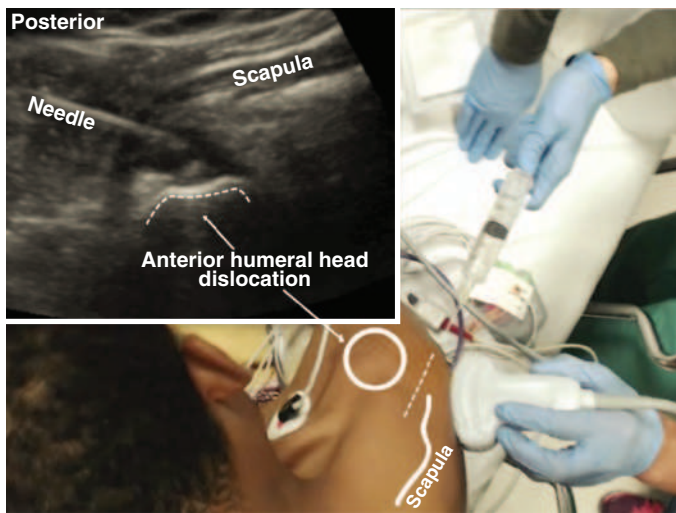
Ultrasound-guided intraarticular glenohumeral injection for shoulder dislocation reduction. Dislocated joints are readily anesthetized with intraarticular local anesthetic injection. For shoulder dislocation, the ultrasound-guided posterior approach is reliable and effective. The needle (*dashed line*) is advanced anterior and lateral to the scapula into the glenohumeral space, where 20 mL of lidocaine is then slowly injected.
